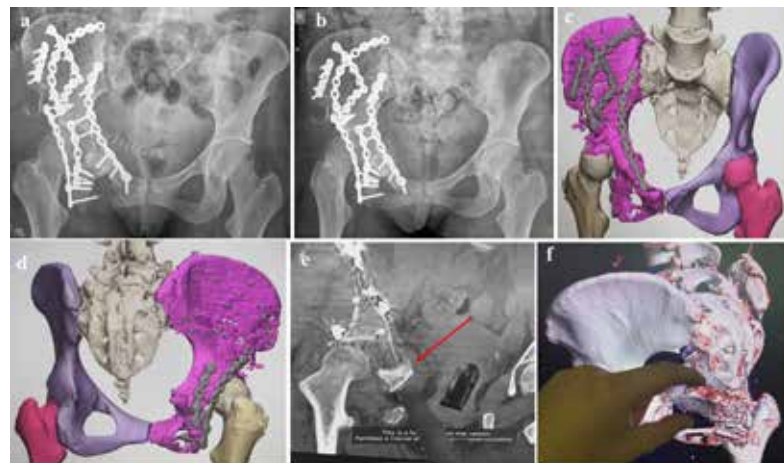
Case 3. *a, b)* malreduced hip was confirmed in serial views and xrays, *c, d)* metalwork found in good position, *e)* CT scan coronal view. Finger and red arrow showing spur of malreduced rotated Quad invading cotyloid fossa and narrowing joint forcing head to sit abnormally, *f)* 3D Recon finger showing quad malrotation
